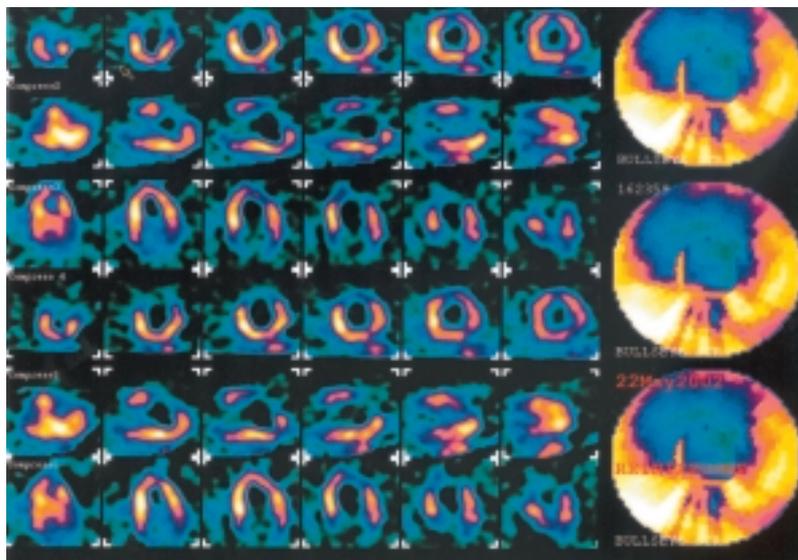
Case 2: thallium-201 myocardial scintigraphy which showed a clear non-reversible anterior and apical perfusion defect.
